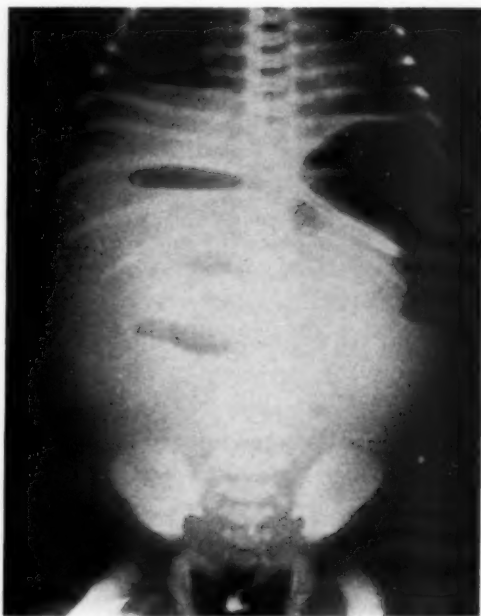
Meconium ileus associated with gangrene of the bowel. Upright roentgenogram of the abdomen demonstrating isolated loops of bowel with fluid levels.
